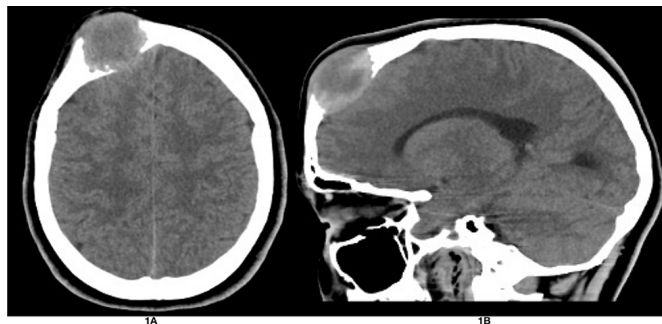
Head CT scan soft tissue window Axial (1A) and Sagittal (1B) demonstrating a well-circumscribed intradiploic exophytic hypodense soft tissue mass lesion with surrounding bone destruction of the right frontal bone (involving both tables of the skull vault) minimally indenting the right frontal lobe. No underlying brain edema.
